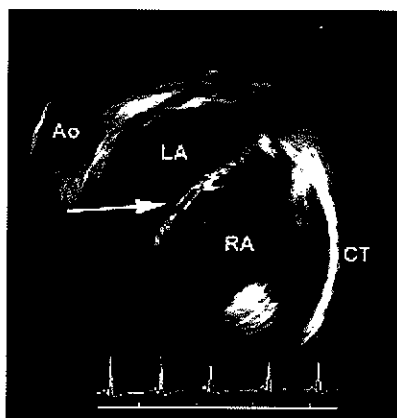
A rare case: a double membrane is clearly visible in the fossa ovalis. Next to the left atrium the aortic arch is visualised. Ao, aorta; CT, crista terminalis.
